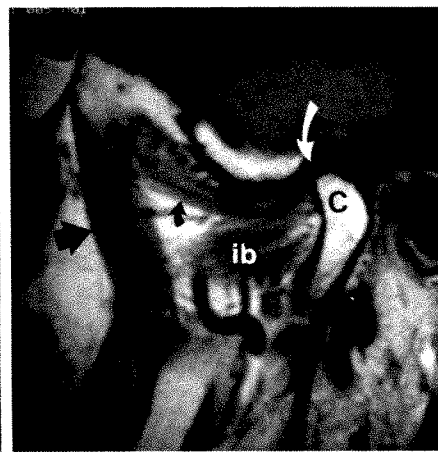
Normal pterygoids and TMJ in 61-year-old female volunteer with average build. Sagittal MR image, 600/20, with mouth closed, shows normal medial (large black arrow) pterygoid. Superior (curved black arrow) and inferior (ib) bellies of lateral pterygoids control TMJ meniscus (curved white arrow) and mandibular condyle (c), respectively.
